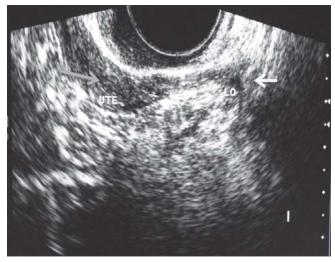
Sonographic relationship of the left gonad with the uterine corpus. The red arrow showing the infantile uterine corpus and the yellow arrow showing the left gonad.
